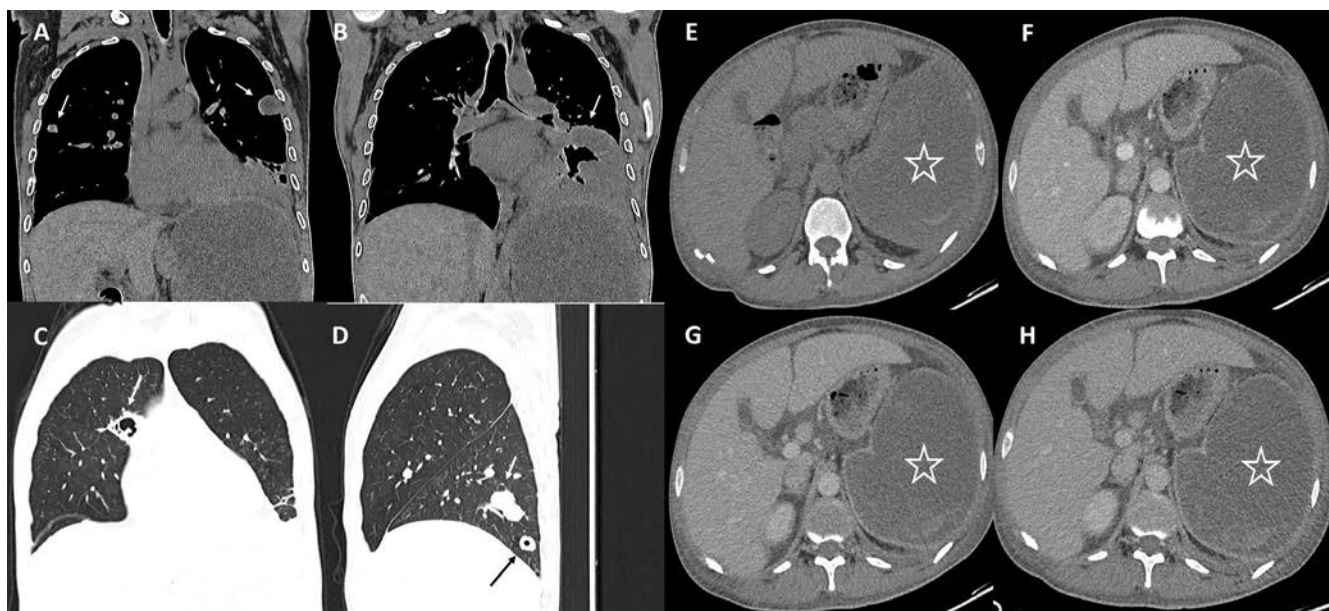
In the coronal mediastinal window, solid nodules in the right and left lung (white arrow) (A), and large nodule with cavitation in the lower lobe of the left lung (white arrow) (B). In the lung parenchyma window, paramediastinal cavitory nodule in the right lung (white arrow) (C), adjacent solid (white arrow) and cavitory (black arrow) nodules in the posterior lower lobe of the right lung (D). Axial abdominal CT sections, without contrast (E), arterial (F), portal (G), splenic infarction showing size increase in venous phase (H), hypodense in all series, no contrast enhancement in contrast-enhanced series (asterisk).
